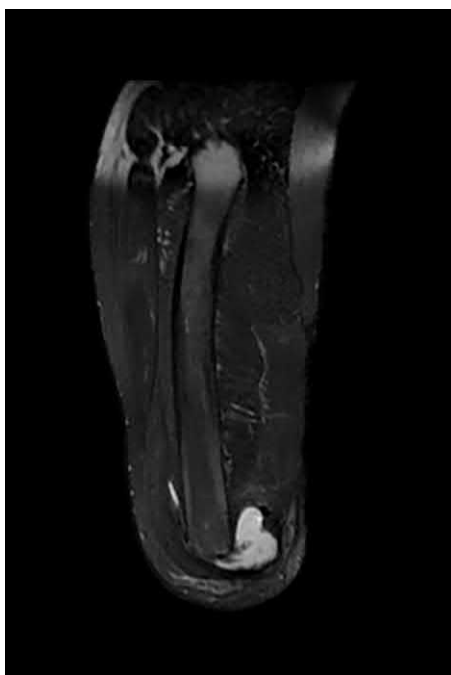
Sagittal T2 sequence magnetic resonance imaging of transfemoral amputation demonstrating fluid collection at the distal end of the residual femur.
